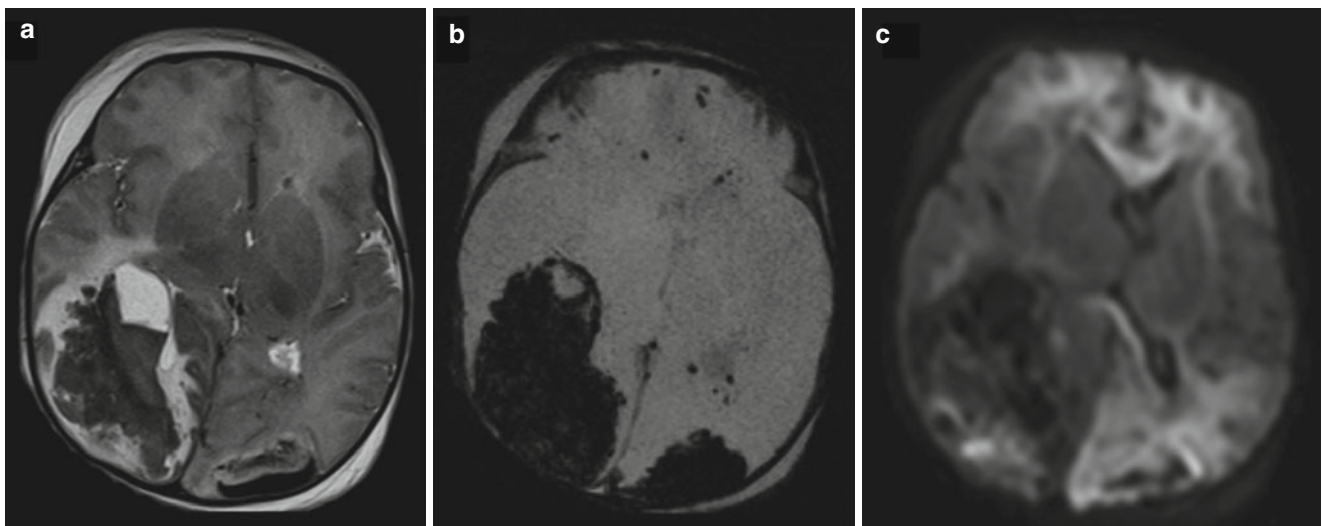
Axial T2-weighted MR image (a), axial SWI MR image (b), and axial trace of diffusion MR image (c) in a child with liver failure and consequent coagulopathy. In addition, the patient was resuscitated from cardiac arrest. The axial T2-weighted image and SWI image (a) show extensive intraparenchymal hemorrhages in the right parieto-occipital region and to a lesser extent in the left
